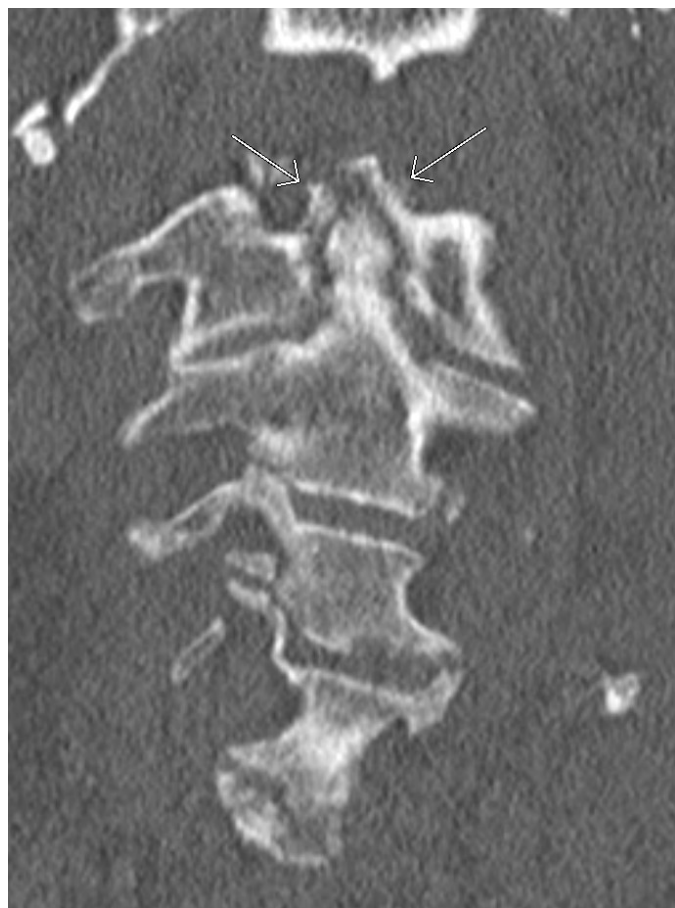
CT C-spine without contrast: mineralization of the ligaments surrounding the dens process consistent with calcium pyrophosphate dihydrate deposition
